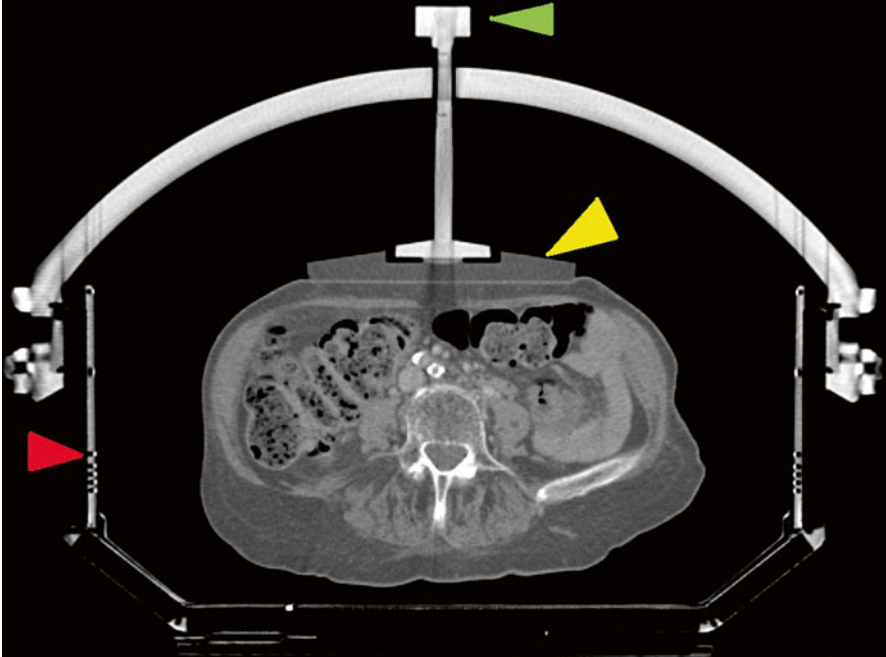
A CT scan slice through the whole body frame. *Red arrow*, the whole body frame; *yellow arrow*, abdominal plate; *green arrow*, screw to regulate the degree of abdominal compression
